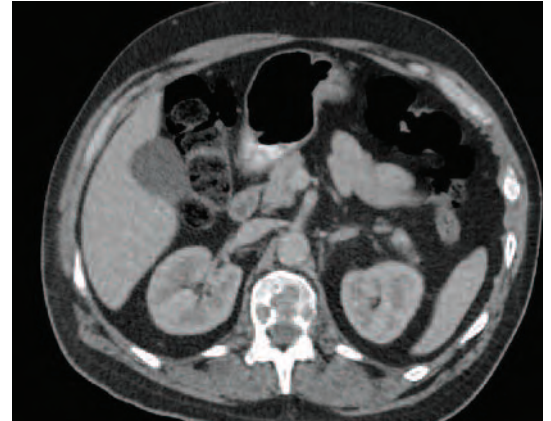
Transverse section of a thorax/abdomen/pelvis (TAP) CT without contrast at the level of L1, showing several metastatic lesions in the vertebral body.
